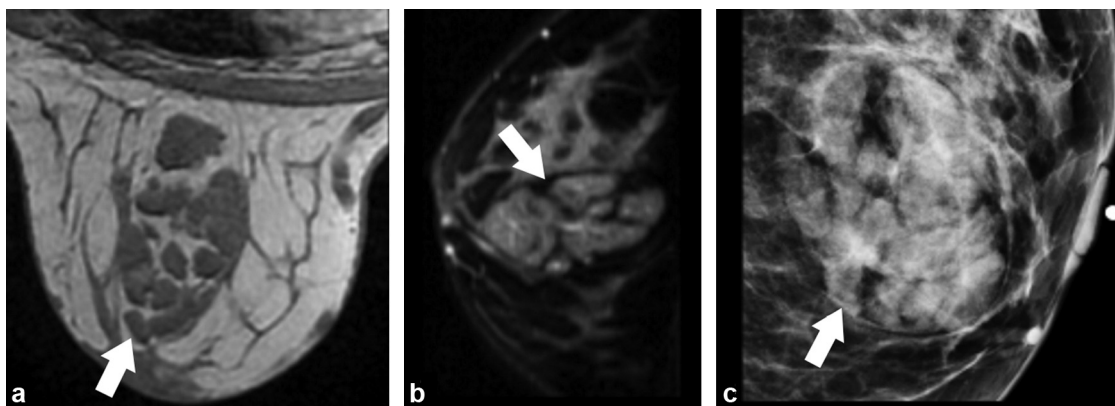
A 31-year-old woman undergoing MR examination for palpable abnormality without mammographic or sonographic correlate. (a) T1-weighted MR image obtained in the transverse plane demonstrates a fat-containing mass unrelated to the palpable abnormality compatible with known hamartoma (arrow); (b) T2-weighted fat-suppressed MR image obtained in the sagittal plane of the hamartoma demonstrates the interwoven fat within the mass (arrow); (c) cropped mediolateral oblique mammogram of the hamartoma (arrow).
